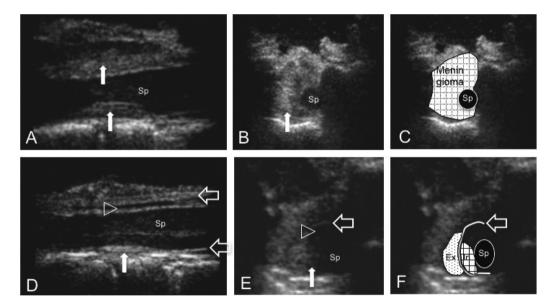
Sagittal (A) and axial (B, C) intraoperative ultrasonography after laminectomy show the tumor surrounding the spinal cord; however, it could not detect the intradural tumor. Sagittal (D) and axial (E, F) ultrasonography after mass reduction of the extradural tumor reveals the dura mater (leftwards thick arrow), cerebral spinal fluid (rightwards arrow head), and intradural tumor (upwards arrow). Sp: Spinal cord, Ex: Extradural meningioma, In: Intradural meningioma
